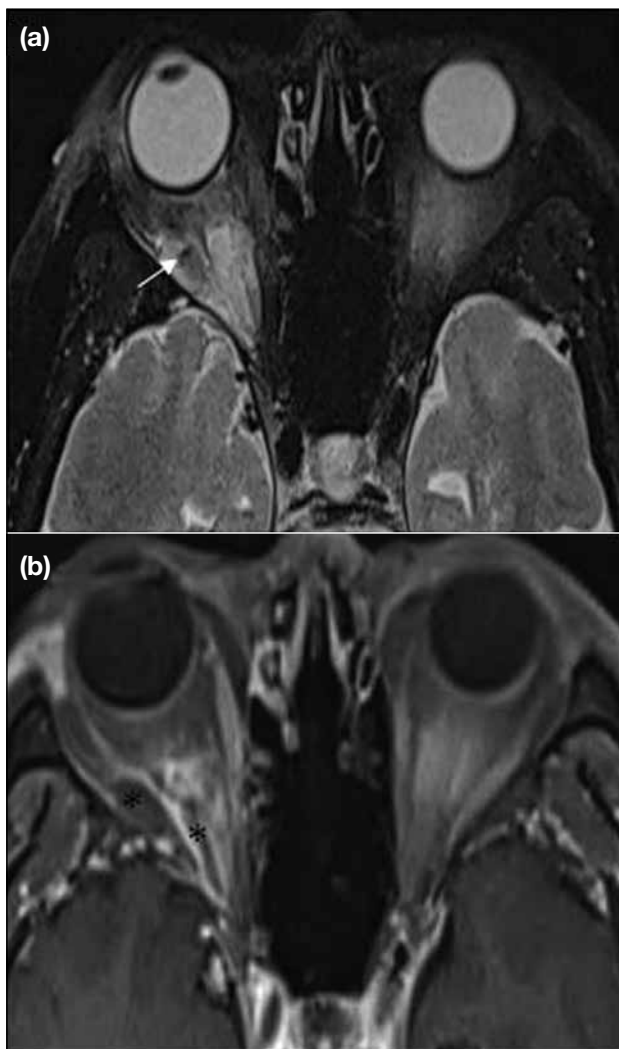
(a) Magnetic resonance imaging T2-weighted fat-suppressed image shows hyperintense right retro-orbital lesion with hypointense signal within (arrow). No serpiginous signal void within the lesion suggests arteriovenous malformation. (b) Post-gadolinium T1-weighted fat-suppressed image shows enhancement of the lesion with tubular filling defects (asterisk) within, consistent with thrombosis of the orbital varix.
